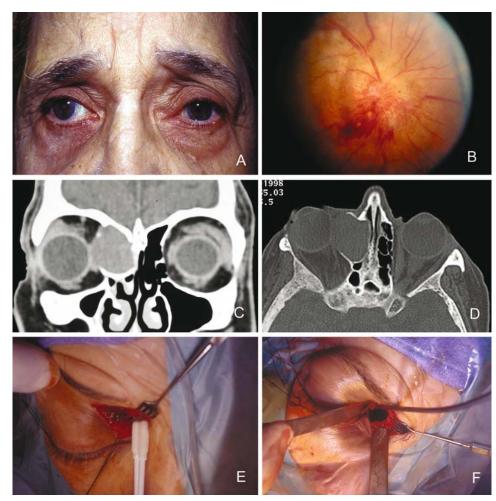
(A,B) Facial photograph of patient in whom a frontoethmoidal mucocele of the right orbit was causing proptosis. In addition, there was lateral dislocation of the globe, extraocular motility disturbance, and compressive optic neuropathy. (C,D) Coronal and axial (bone window) CT scans delineate the lesion accurately. (E) Superior medial orbitotomy is initiated through a Lynch incision and the mucocele is exposed. Note that the mucocele luminal contents are being cultured at this stage. (F) Later the mucocele cavity was fully exposed by removing mucosal and bone elements of its wall.
